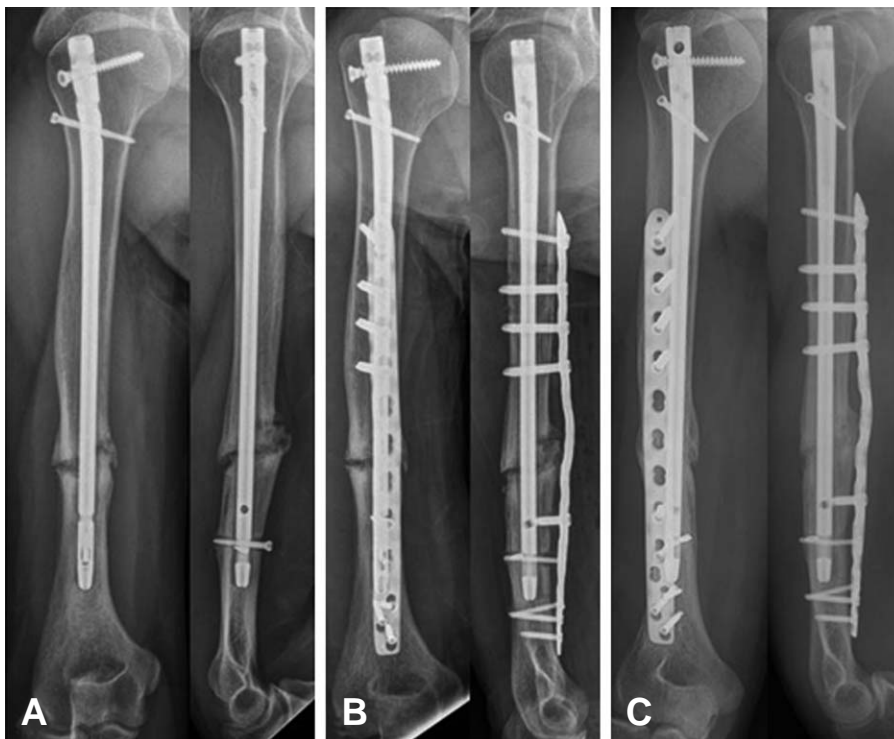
(A) 27-year-old male with Hypertrophic Nonunion after CR IMN (B) Increased Stability with Augmentation Plating (4.5 LC DCP) (C) Radiographic Union at 6 months after Augmentation Plating.
